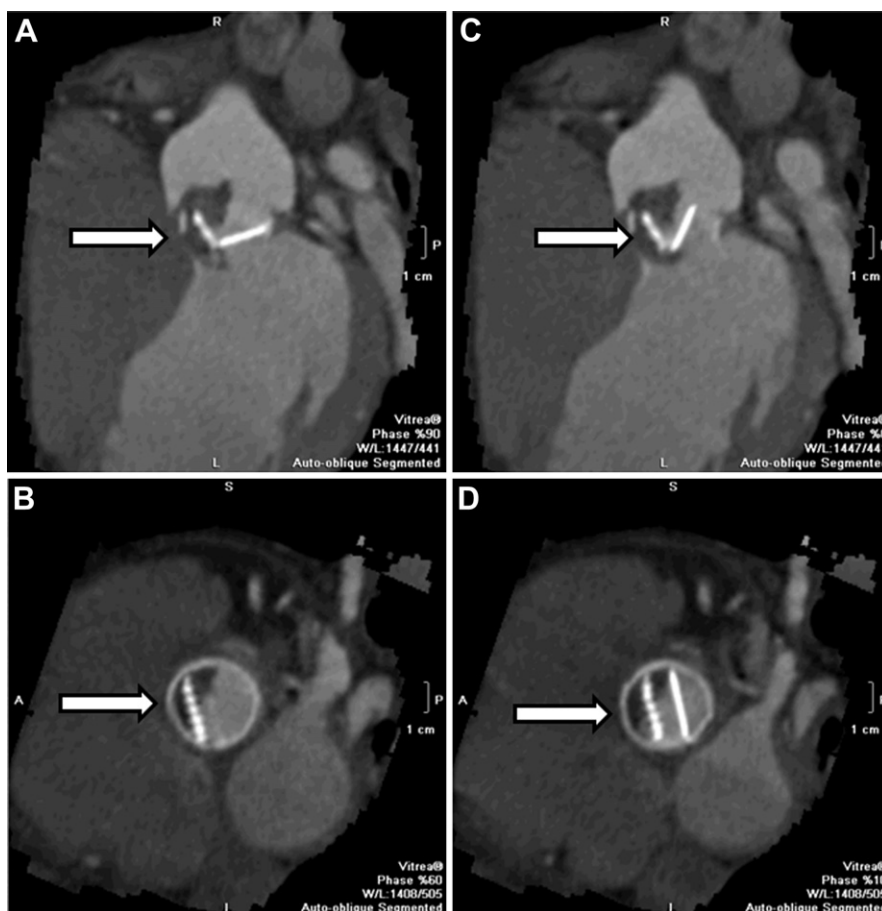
Multidetector computed tomography angiography shows a malfunctioning St. Jude mechanical aortic valve because of thrombus on the right leaflet (*arrow*), interfering with leaflet closure with minimal movement in diastole (A and B) and systole (C and D).
